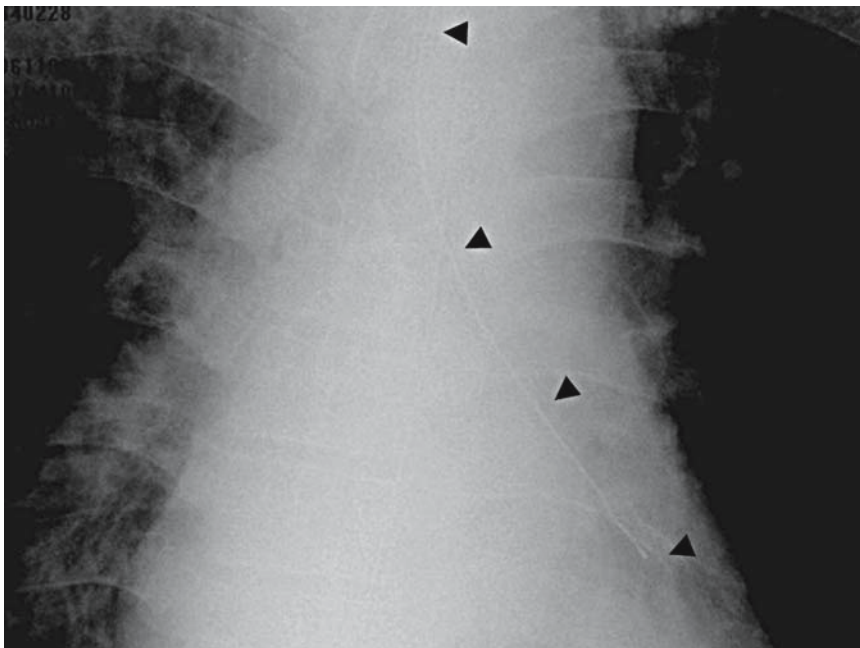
Chest X-ray, showing the misplaced thermal probe tip (*black arrowheads*) in the left main bronchus
